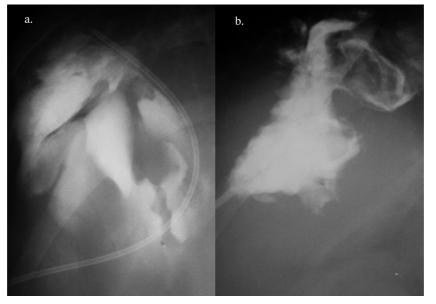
(a) X-ray with contrast medium via the drainage catheter on the day the cyst was drained shows a large multilobular form but no communication with biliary tract. (b) The cyst cavity has decreased in size 21 days after the drainage.
